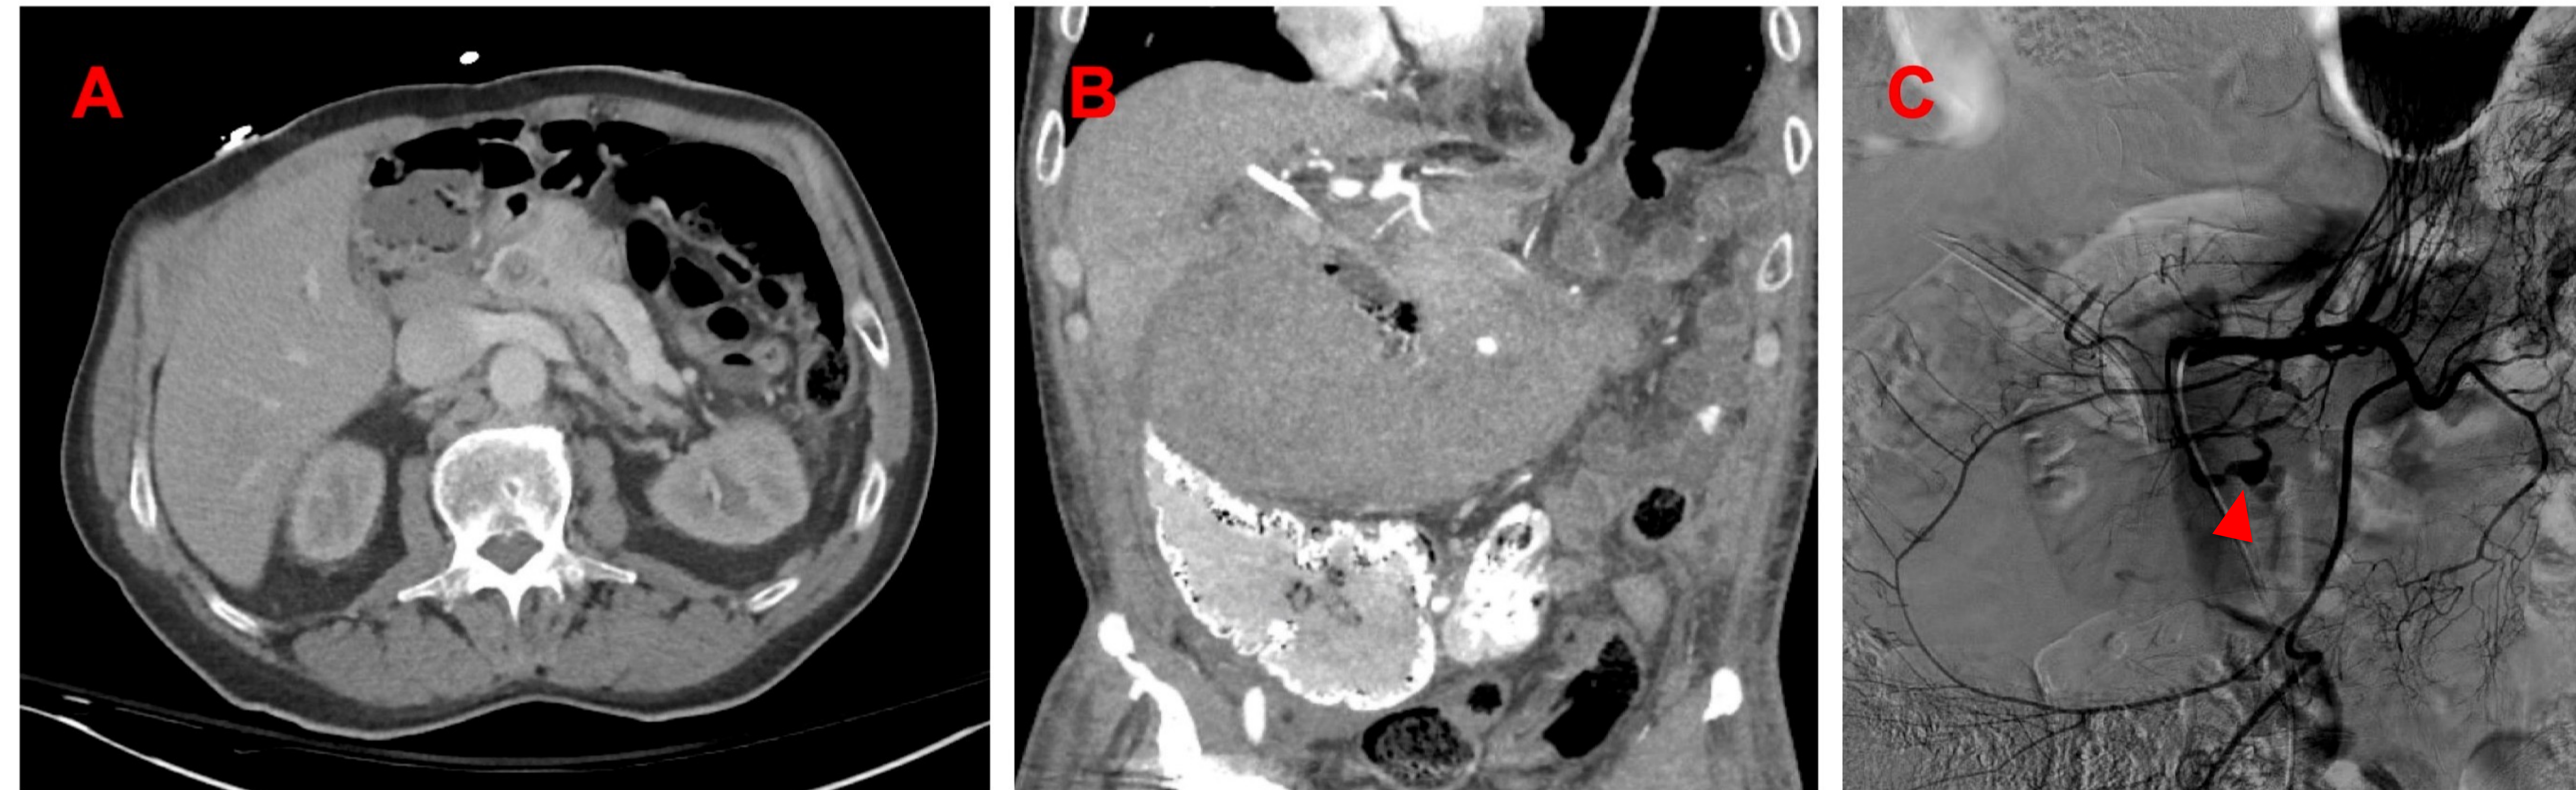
(A) CT with contrast showing choledocholithiasis with a 1.2 cm stone in the head of the pancreas. (B) CT angiography showing active extravasation and a pseudoaneurysm (PSA) within an intra-abdominal hematoma (18.4 x 8.5 cm). (C) Mesenteric angiography which showed one multilobulated (2 x 1.8 cm, arrowhead) and one smaller PSA arising from an inferior pancreaticoduodenal artery branch.
